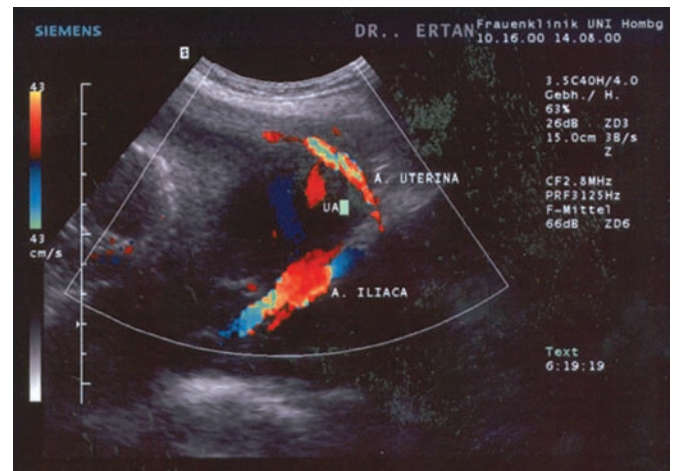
Color Doppler sonographic view of the main uterine artery crossing the iliac artery.
